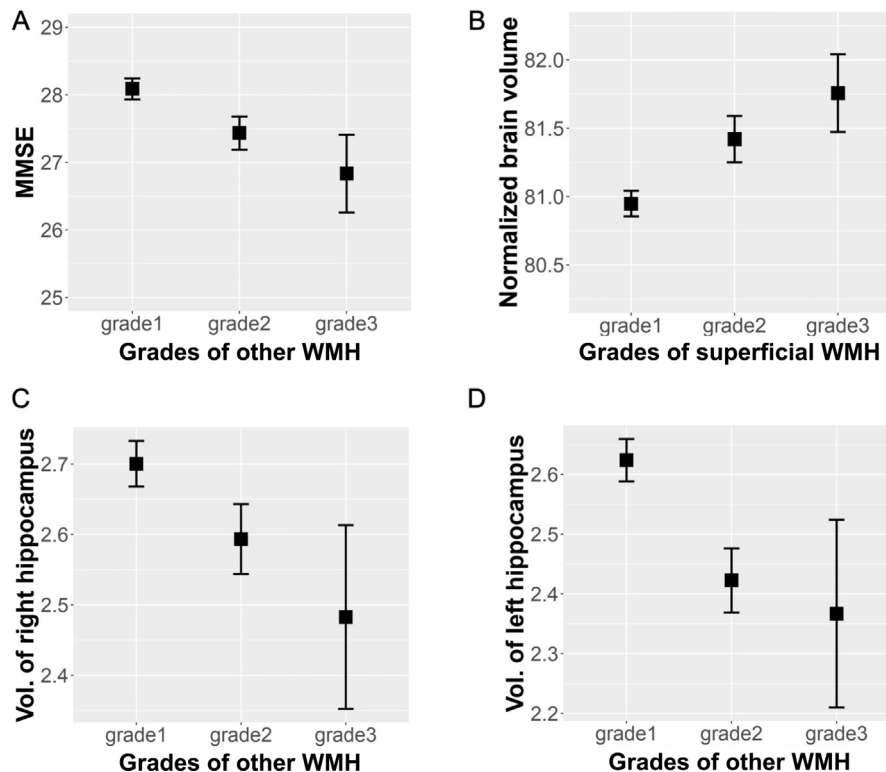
Main relationships between white matter hyperintensities and morphological MRI markers and clinical outcomes. A. Higher grades of other WMH are associated with lower MMSE scores. B. Higher superficial white matter grades are associated with larger normalized brain volumes. In contrast, other WMH grades are associated with smaller hippocampal volumes on both sides (C and D). WMH: white matter hyperintensities; MMSE: mini-mental state examination.
